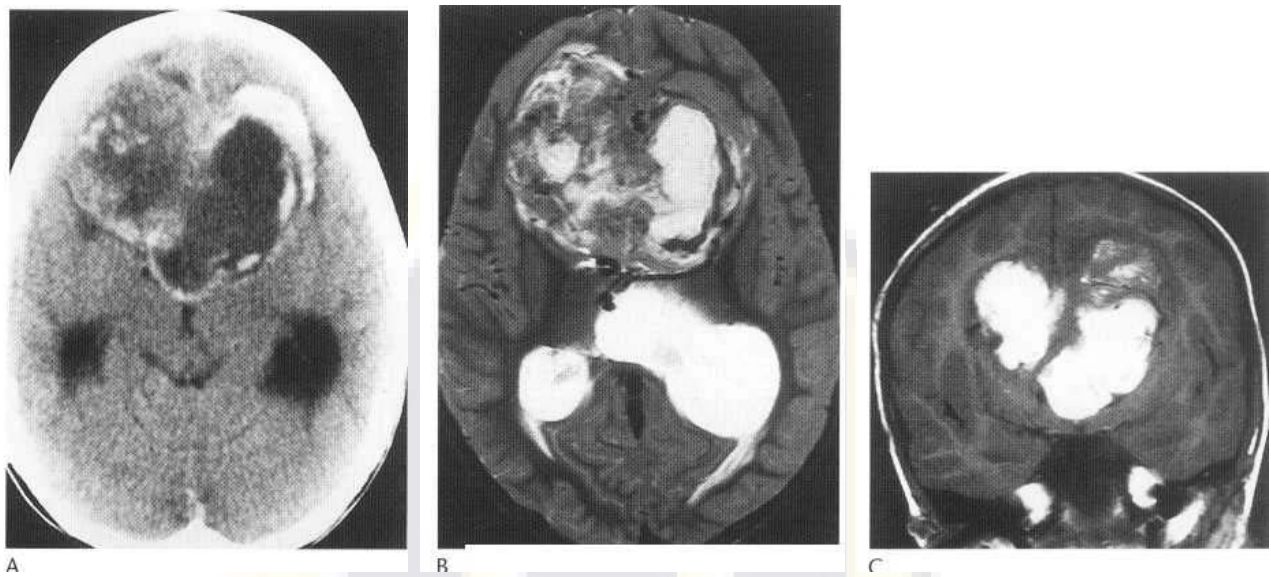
Axial unenhanced CT (A) showing a large complex bifrontal partially cystic haemorrhagic tumour proven to be a glioblastoma. The T_2 signal characteristics are complex (B) and the coronal T_1 unenhanced image (C) shows large T_1 hyperintense components due to the presence of methaemoglobin. There is no significant vasogenic oedema despite tumour size but there is resultant obstructive hydrocephalus with early transependymal oedema around the occipital horns.
